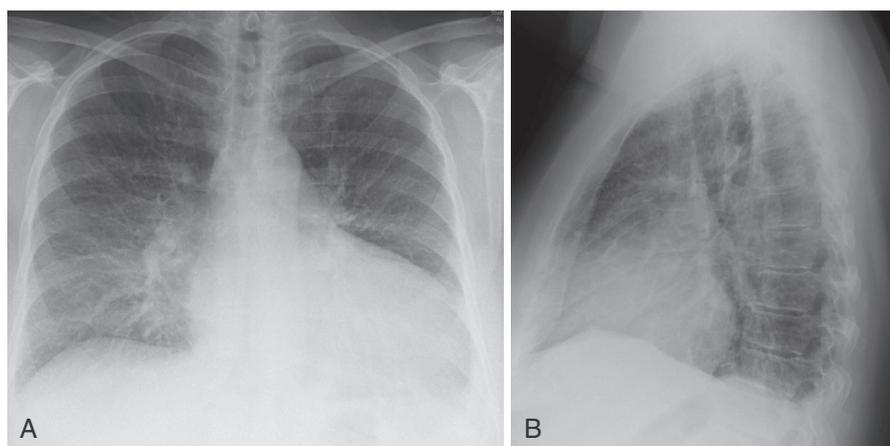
PA (A) and lateral (B) chest radiographs in a patient with left ventricular dilation and pulmonary edema. PA view shows venous cephalization, blurring of pulmonary vascular margins, and fissures and Kerley B lines. Lateral view shows pleural effusions.
